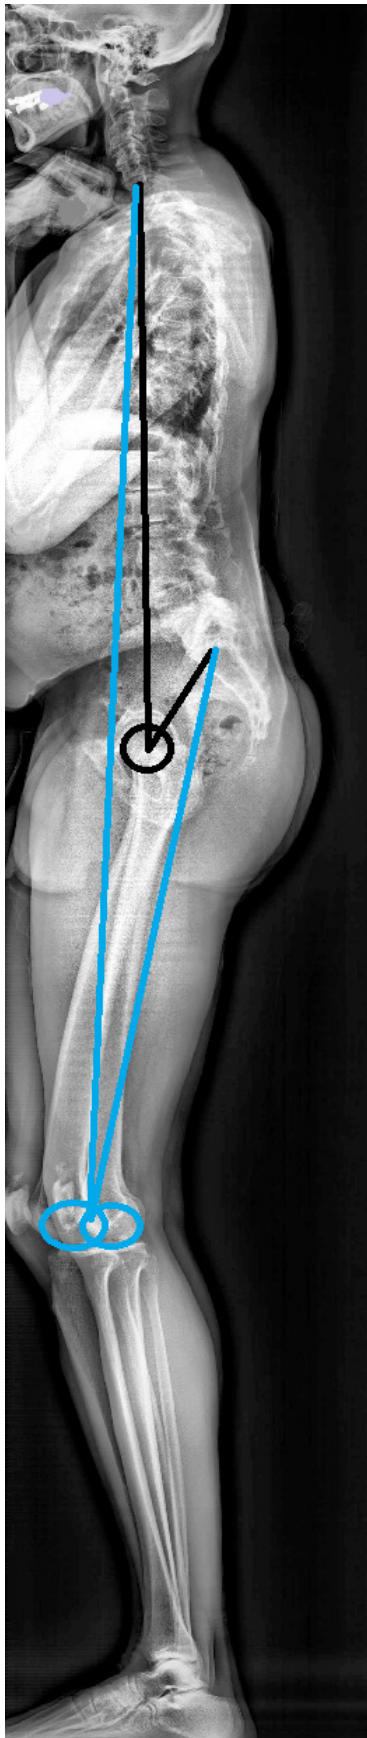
Example of measuring GSA on a radiograph
